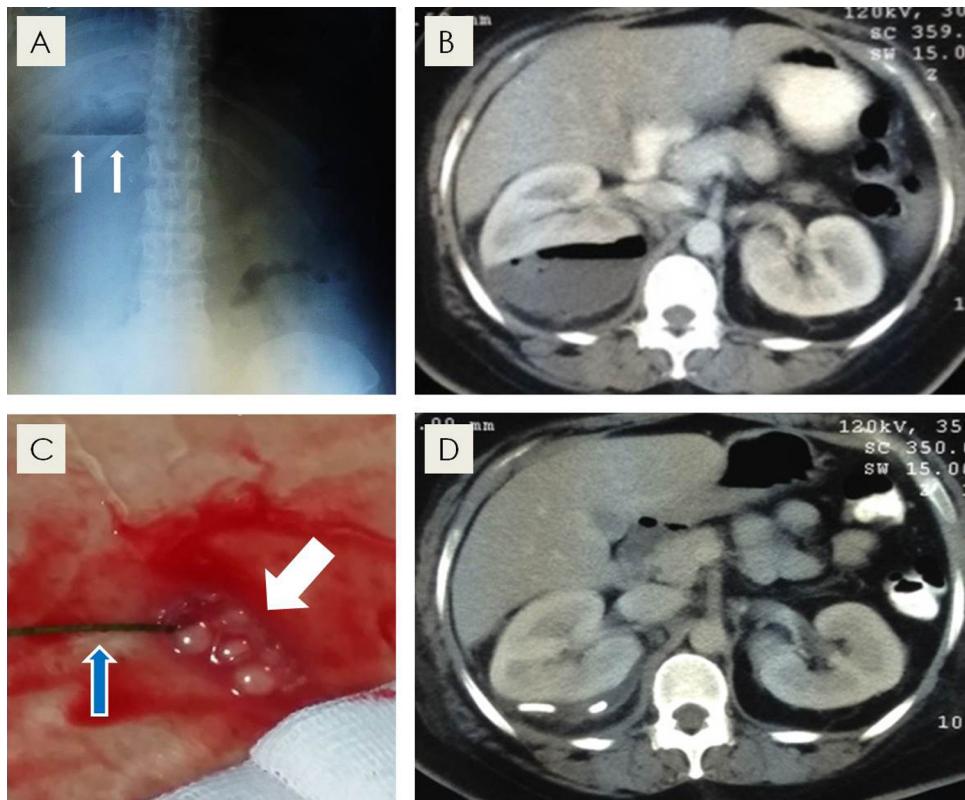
(A) Plain (erect) abdominal X-ray, revealing the underlying air-fluid level (arrows). (B) Contrasted CT scan of the abdomen (transverse view) showing the gas and fluid collection – typical findings in EPN. (C) Gas bubbles (thick arrow) were visualised during the dilation of the nephrostomy (PCD) tract. The access guide-wire is identified in the photograph (thin arrow). (D) Post-intervention contrasted CT scan of the abdomen (transverse view) with the nephrostomy coil seen within the collection.
